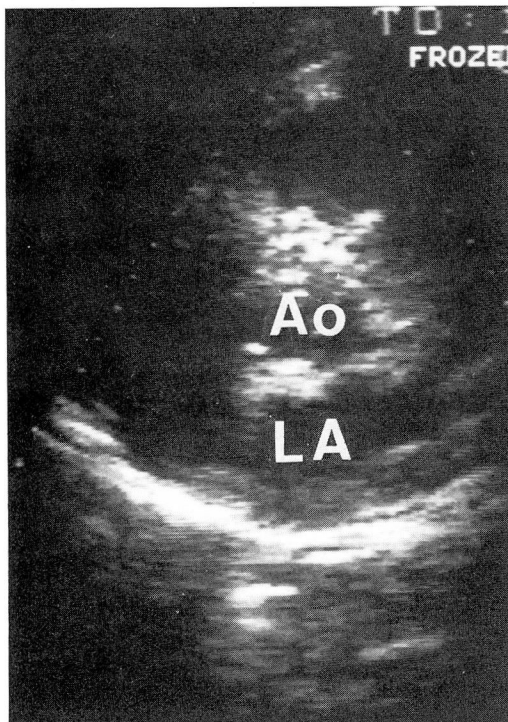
Postoperative two-dimensional echocardiogram, short axis view at the level of the aortic valve. There is no evidence of a round mass anterior to the aortic root as seen in Figure 1. (Ao = aorta; LA = left atrium.)
